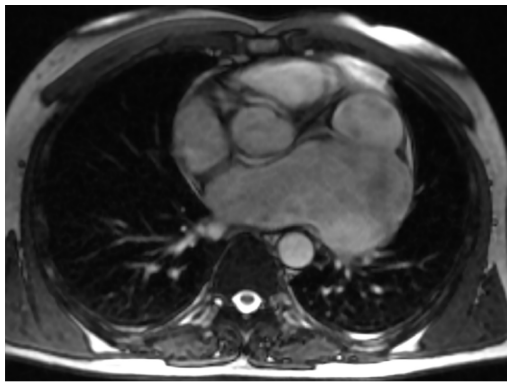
Magnetic resonance imaging. A white arrow shows a sharply dilated cavity of the left atrial appendage.
